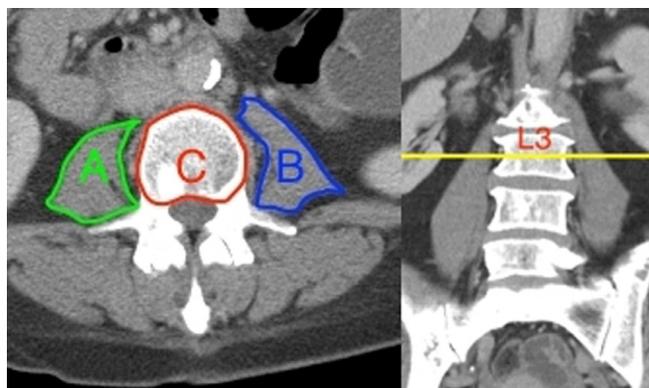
Measurement technique of psoas surface area. All measurements were made using the surface area measurement tool included in the PACS software. The transverse CT scan cut at the level of the middle of the L3 vertebral body was used to measure area. The L3 Total Psoas Area/ Vertebral Body Area (L3-TPA/VBA) was the sum of the right (A) and left (B) psoas area was divided by the area of the L3 vertebral body.
